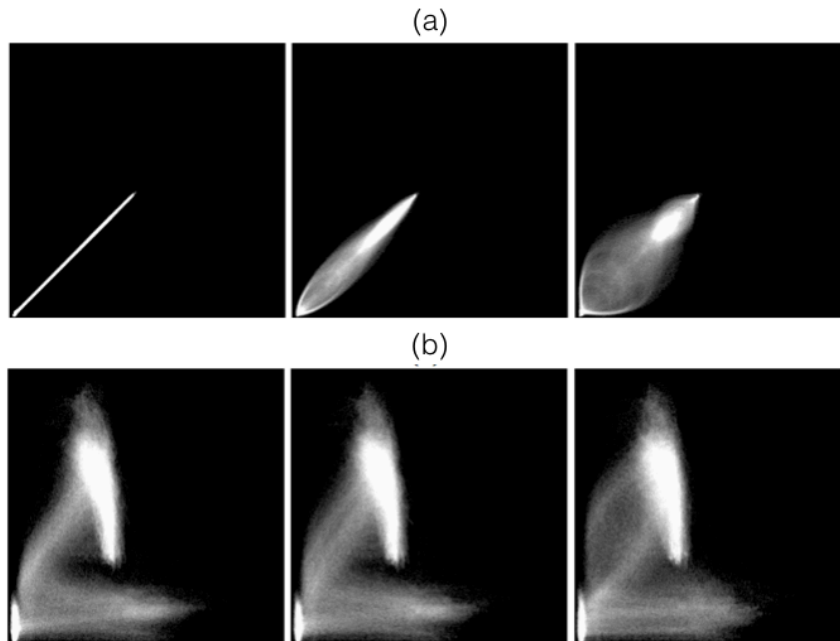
Intensities from the reference image are plotted along the horizontal axis, and those from the moving image on the vertical axis. In row (a), reference and moving images are identical MR images of the head. In row (b), the reference image is an MR image of the head, and the moving image a PET image of the head. For all modality combinations, the histograms are calculated for three different transformations: the identity (left), a lateral translation of 2 mm (centre) and a lateral translation of 5 mm (right) (Fitzpatrick et al. 2000).
